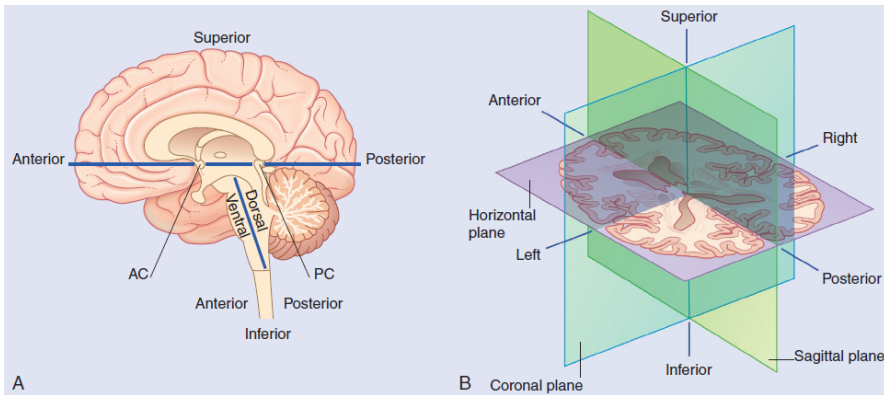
(A) Planes of reference with orientation labels for the CNS. Due to its obliquity, the brainstem is an exception to the overall standard. In some literature, the terms ventral/dorsal are used to refer to the anterior/posterior aspects with respect to the spinal cord. Similarly, the terms rostral/caudal describe the superior/inferior orientation in the brain. The blue horizontal line represents the bicommissural plane (AC = anterior commissure, PC = posterior commissure). In MRI, the horizontal plane is typically called *axial* plane. (B) Cross-section of the brain in the bicommissural plane [28].
